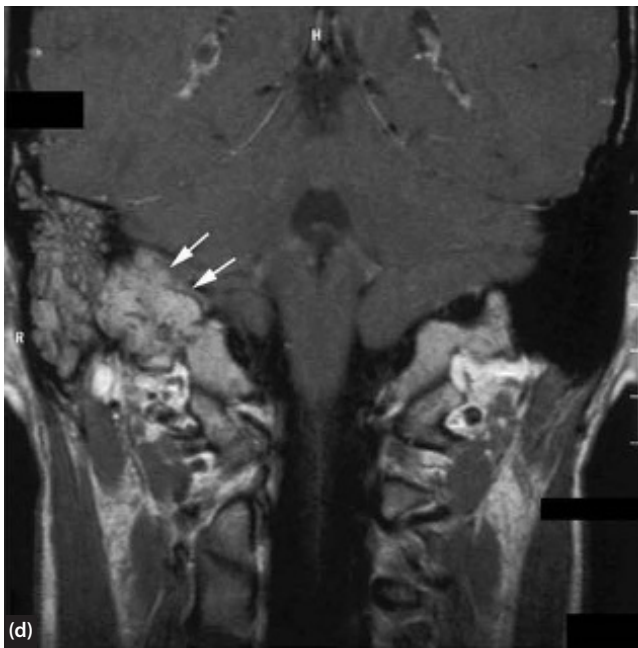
(Continued) A 25-year-old woman presented with right-sided mixed sensorineural-conductive hearing loss of about 60 dB and pulsatile tinnitus. The right tympanic membrane had a reddish-blue discolouration. (d) Coronal plane (continued over). (e) Demonstrating the tumour in proximity of the internal auditory canal. (f) Axial CT scan showing a large defect in the temporal bone (asterisk); note the absence of the bony contour of the internal carotid artery (arrow). (g) Coronal CT scan; the tumour extends from the jugular bulb in a cranial direction and has filled the middle ear. Diagnosis: glomus temporale tumour, a class D lesion according to the classification of Fisch.⁹
